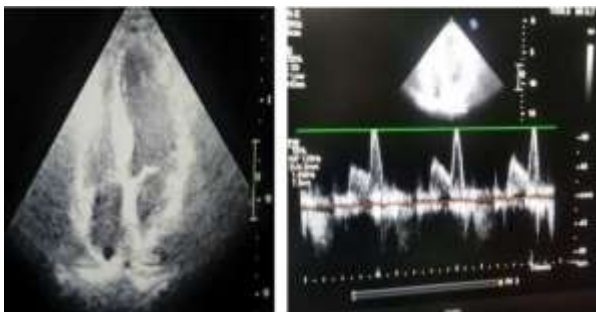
Apical four-chamber view echocardiography Left ventricular (LV) thickening free wall is seen. No evidences of both dilated atria and interatrial septum are seen. Any evidences of thickening of mitral and tricuspid valve cusps are not seen as well.
